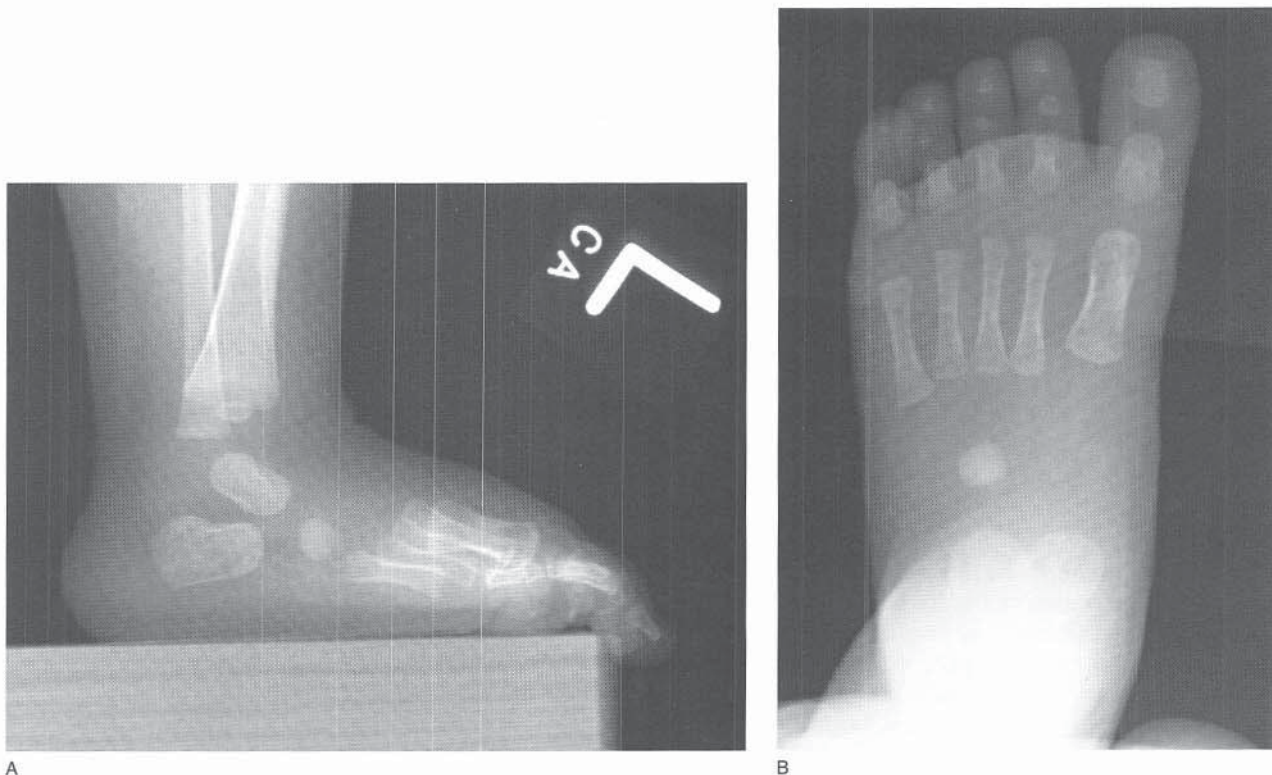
A, Lateral radiograph of a newborn foot. The cuboid is the only ossified midtarsal bone. Note the convergent talocalcaneal angle. B, AP radiograph of a newborn foot. The cuboid is ossified, but no ossification is present in the navicular or cuneiform.
